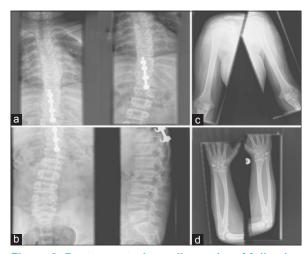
Postero-anterior radiographs of full spine (a, b). X-rays of left and right upper limbs (c, d)
